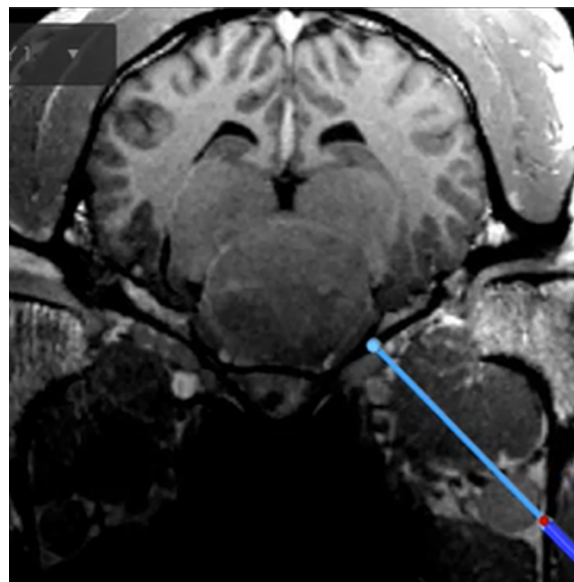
Close-up view of a screen shot of the StealthStation S8 depicting the surgical plan on merged cone beam computed tomography and T1w high-resolution 3D reconstructable magnetization-prepared gradient-echo (3D MP-RAGE) transverse plane images. The light blue line represents the core axis of the corridor to be established as transmandibular lateral transsphenoidal surgical approach to the pituitary macroadenoma.
